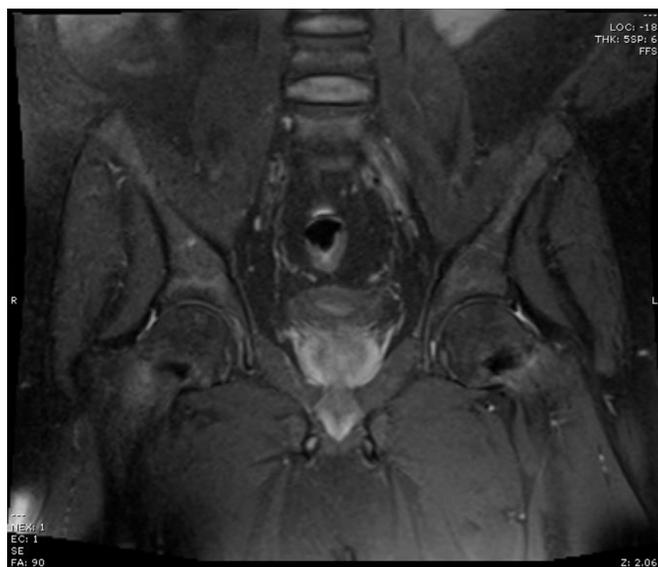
Magnetic resonance imaging scan demonstrating high T₂-weighted marrow signal intensity within the bilateral femoral necks, consistent with recurrent or impending stress fractures.
